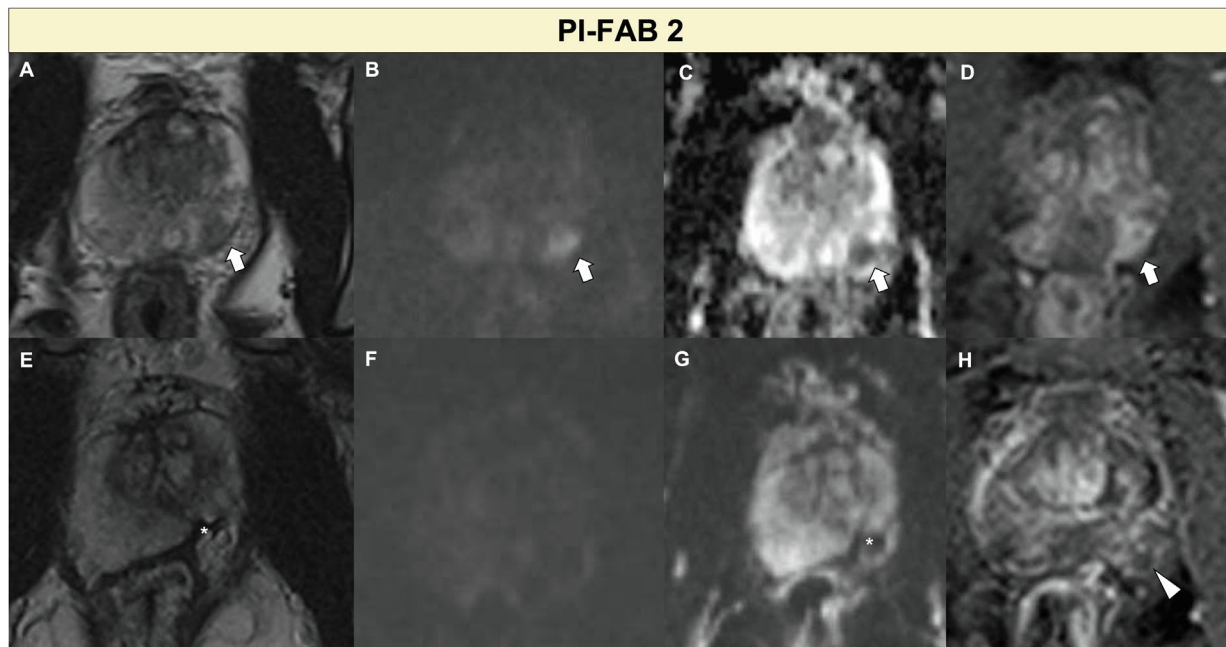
Pretreatment (A) axial T2-WI, (B) high-*b*-value, (C) ADC map, and (D) DCE acquisitions show a lesion in the left peripheral zone at the midgland (arrows; Likert 5/5) treated with high-intensity focused ultrasound. Post-treatment magnetic resonance imaging findings after 5 years show residual fibrosis (asterisks) that is hypointense on (E) T2-WI and (G) the ADC map, with (F) no corresponding hyperintensity on the high-*b*-value sequence but (H) mild enhancement (arrowhead) on the DCE sequence. The Prostate Imaging after Focal Ablation (PI-FAB) score is 2. ADC = apparent diffusion coefficient; DCE = dynamic contrast-enhanced imaging; DWI = diffusion-weighted imaging; T2-WI = T2-weighted imaging.
